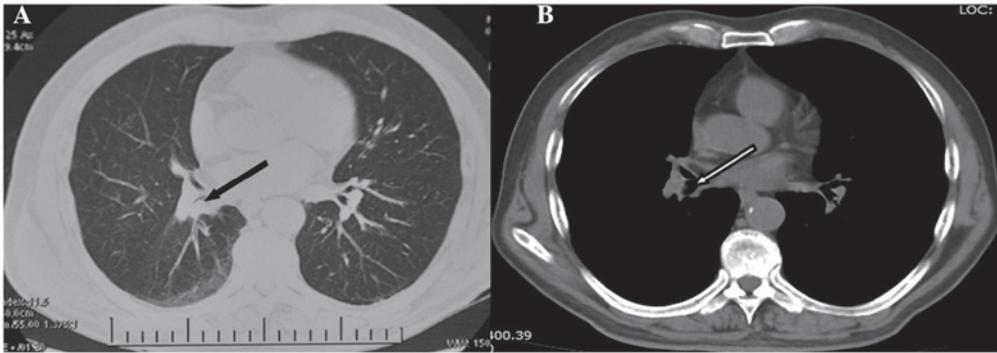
Chest computed tomography scan showing a round mass in the right inferior bronchus occluding the lumen (arrow). (A) Lung window and (B) mediastinal window.
